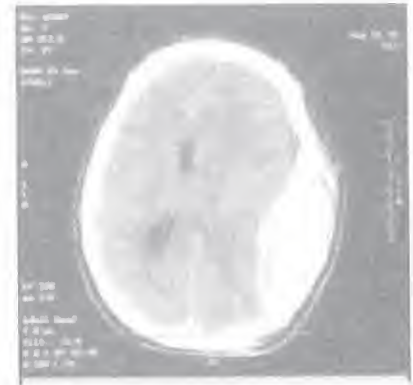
CT scan of head shows an extradural haematoma
